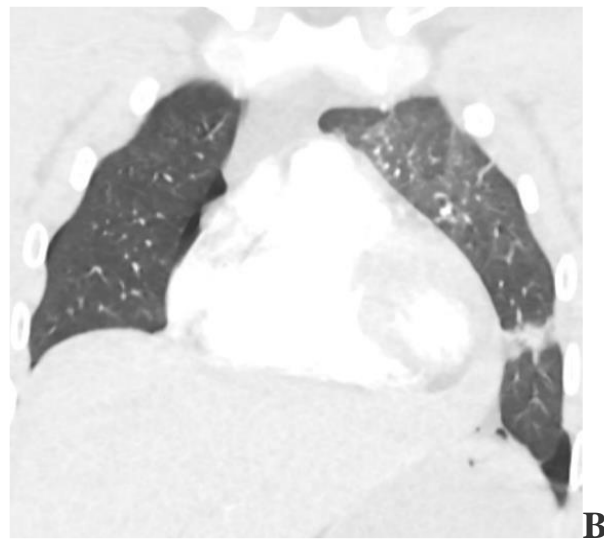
Spiral CT of the chest with contrast enhancement: a blind gunshot penetrating wound of the chest with a through wound to the heart, hemothorax, bilateral partial pneumothorax, left-sided massive hemothorax, no signs of extravasation were found. A – axial plane; B – coronal plane; C – sagittal plane.
